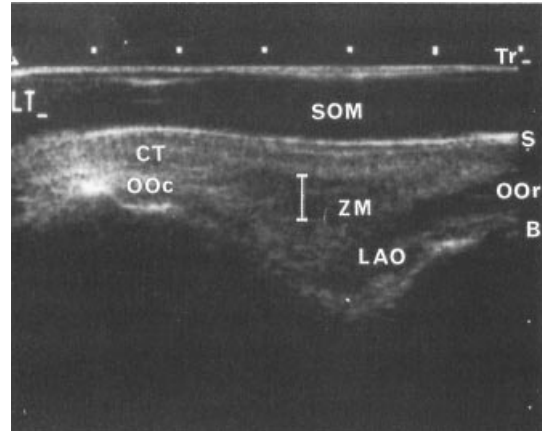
An ultrasound image of the left lip levator musculature with the transducer positioned along line (b) in Figure 1. Tr: transducer; SOM: stand-off medium; S: skin; CT: connective tissue superficial to the muscle; ZM: zygomaticus major muscle; OOr: orbicularis oris muscle; LAO: levator anguli oris muscle; OOr: orbicularis oris muscle; B: bone.
